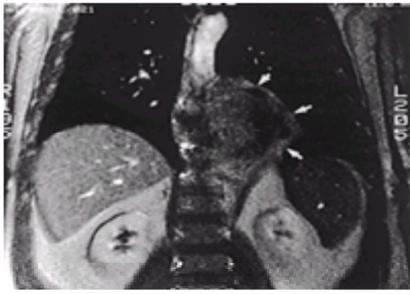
Magnetic resonance image of a large, symptomatic ganglioneuroma (arrows) in a 47-year-old man. [Figure 70-3](#) shows the operative picture.
